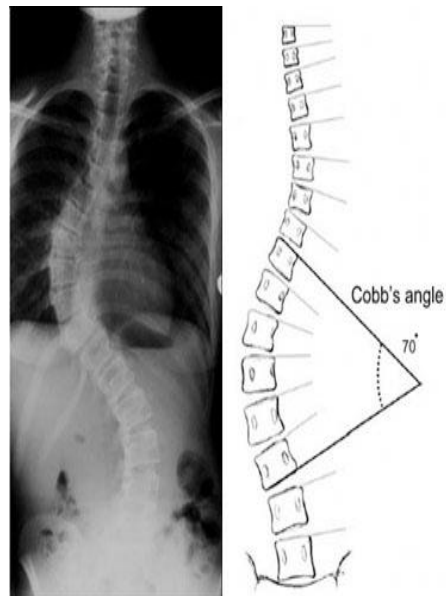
X-ray of scoliosis
